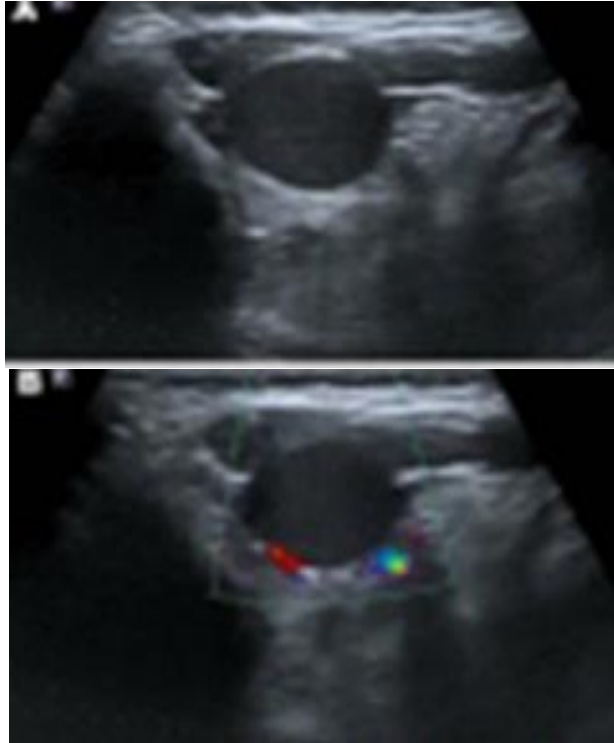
A. Grey scale Sonography of the submental triangle shows an oval mass with well-defined margin and hypoechoic echotexture, B. Doppler sonography shows avascular cystic lesion.
